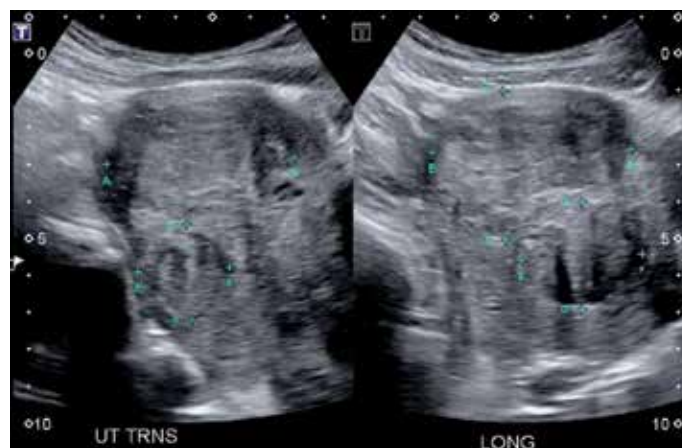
Ultrasound of fibroids.
